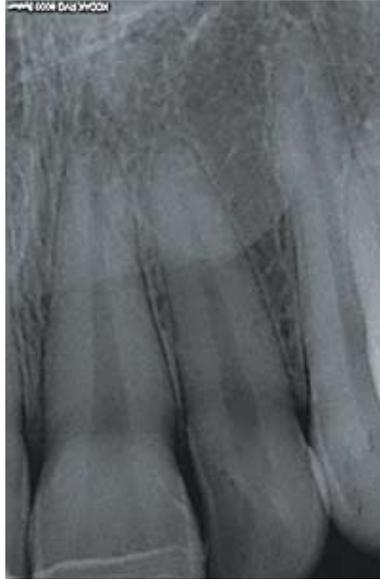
Radiograph of fractured upper left central incisor after provisionalization.
